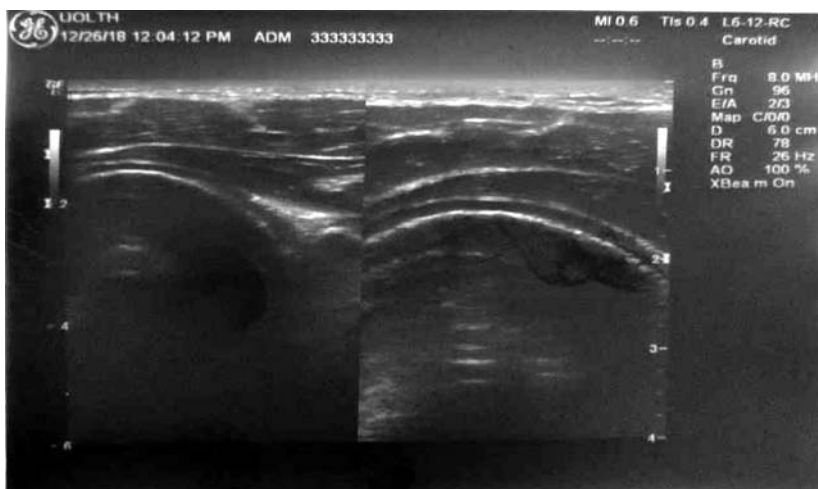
Musculoskeletal ultrasound showing intact rotator cuff muscles.
